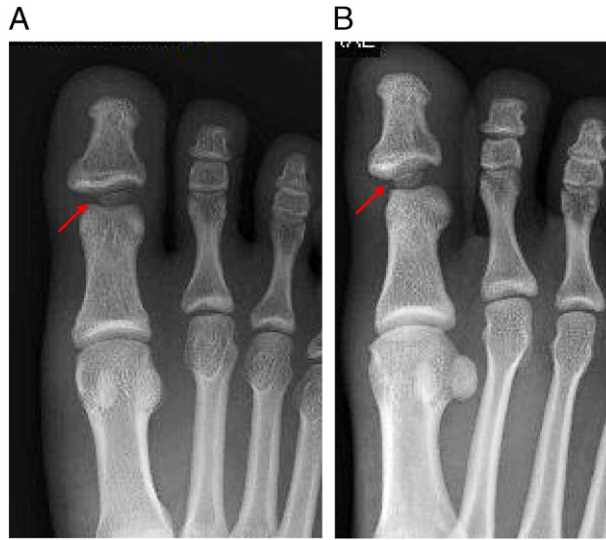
A & B. Plain radiograph (AP and Oblique views) from earlier post reduction procedure showed presence of widening of right IPJ space with hallucal sesamoid noted in situ.
